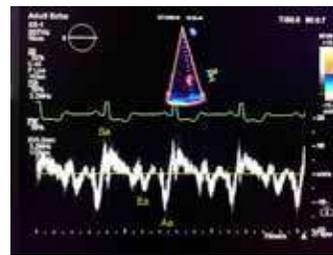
Tissue Doppler Echocardiography image taken from the middle of the left atrium external wall. Aa: Atrial contraction wave (left atrial wall velocity).
